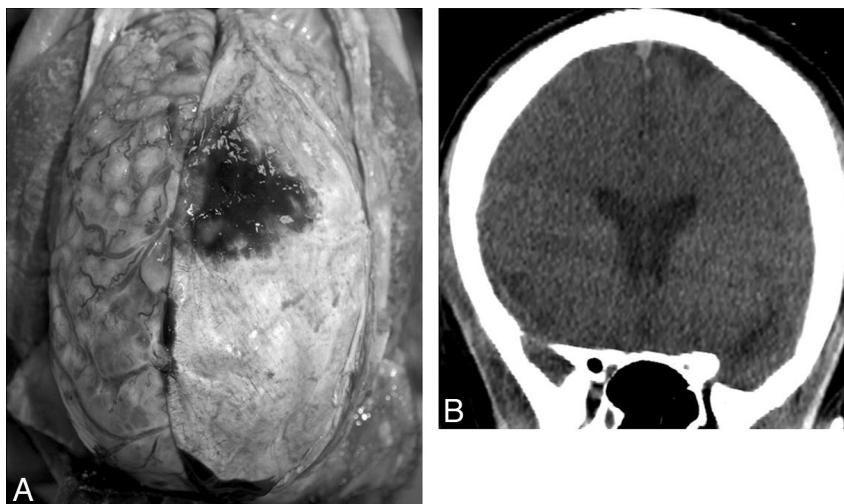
Bilateral subdural hemorrhage not seen on CT. *A*, Photograph from autopsy in which the left aspect of the dura has been reflected to the right, revealing the left-sided subdural hematoma that is adherent to the dura. Note that viewing the brain from above changes right–left orientation from the convention used on CT. *B*, Noncontrast CT coronal reformat from the same subject does not demonstrate subdural hemorrhage. No evidence of hemorrhage was seen on the original axial images or the sagittal reformation.
